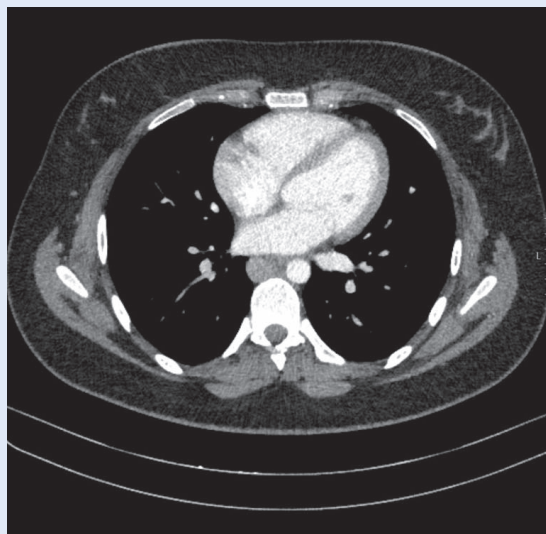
Axial abdominal CT scan – Hemiazygos vein merges into the azygos vein in the thorax area.
